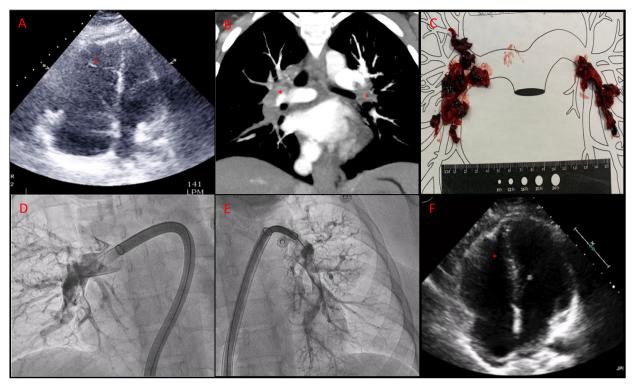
A: Transthoracic echocardiogram (TTE) showing a severely dilated right ventricle (RV) with severe systolic dysfunction. B: Massive pulmonary embolism by computed tomography pulmonary angiogram. C: Large number of thrombi extracted from pulmonary arteries. D: Post-aspiration angiography of the right pulmonary artery with Triever-24F catheter. E: Post-aspiration angiography of the left pulmonary artery with Triever-24F catheter. F: TTE performed 24 h after the procedure showing normalization of the size and function of the RV.
